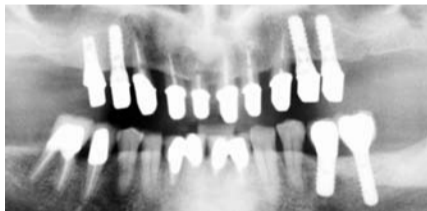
Orthopantomograph taken at the completion of treatment
